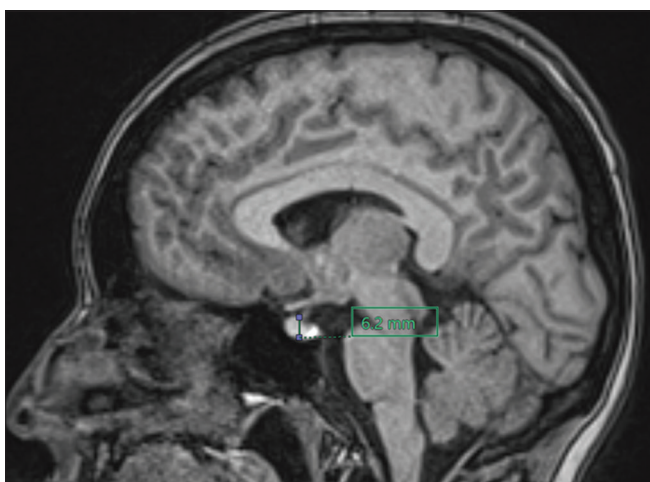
Mid-sagittal magnetic resonance imaging of the brain showing measurement of anteroposterior diameter of the pituitary gland
